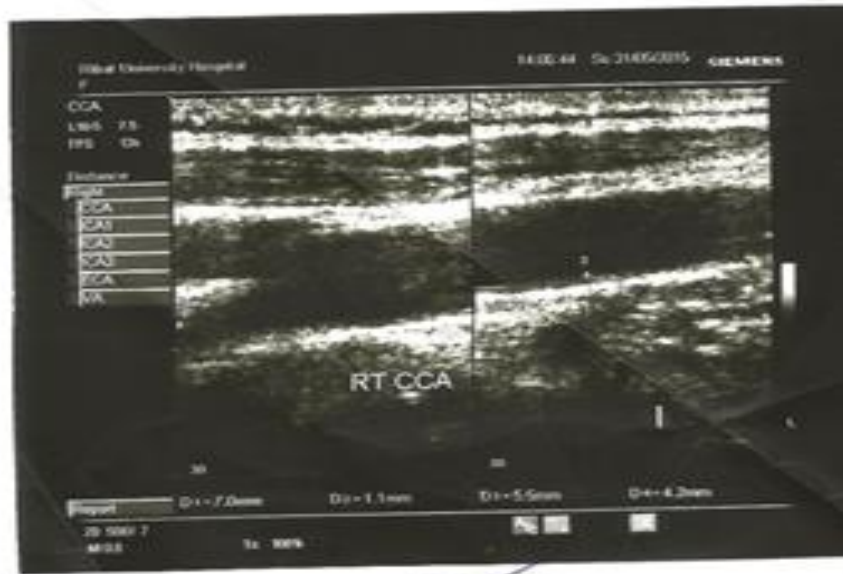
Rt CCA- female- 45 years diabetic patient with normal Doppler parameters.
